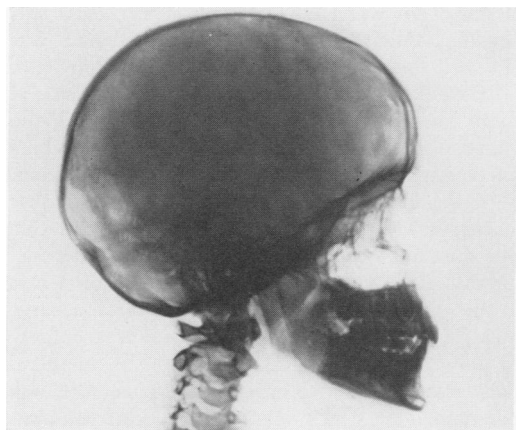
(Case 9.) Four months after biopsy and roentgen therapy. The skull is normal.
